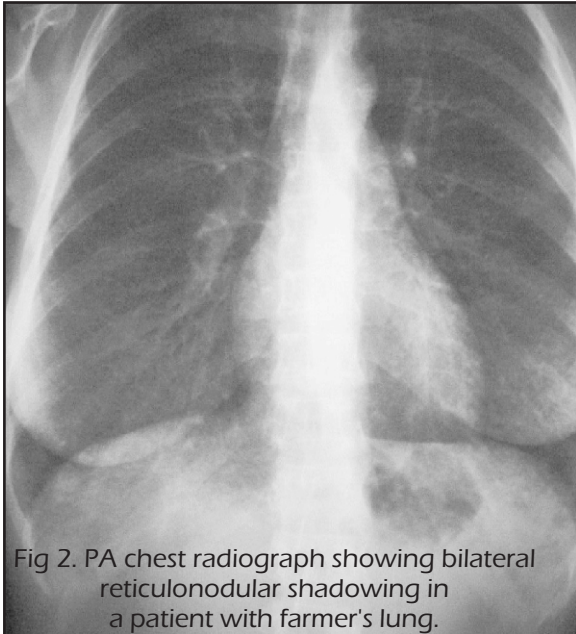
PA chest radiograph showing bilateral reticulonodular shadowing in a patient with farmer's lung.
